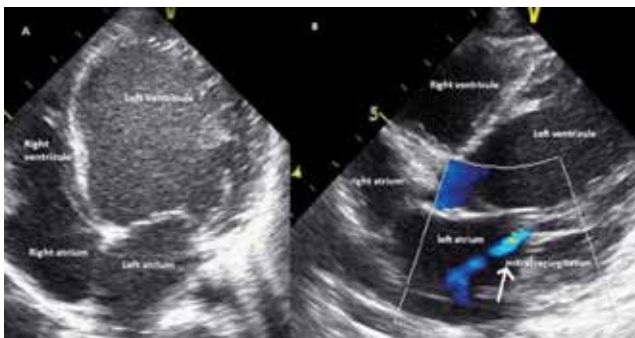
A and B; transthoracic echocardiography images of the patient
